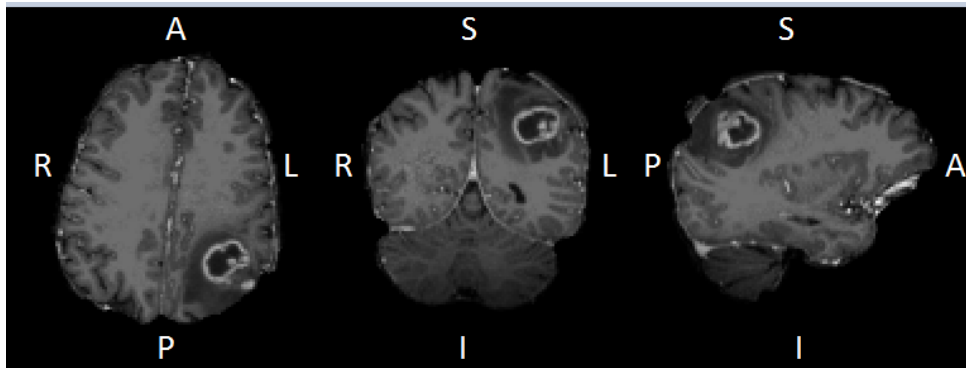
Contrast-enhanced T1-weighted axial, coronal and sagittal cuts of a patient with glioblastoma multiforme located in the left hemisphere (L-left, R - right, A - anterior, P - posterior, I - inferior, S - superior). In this image we can see an area of decreased density (necrotic tissue) surrounded by a bright ring from concentration of the enhancing contrasted dye, which gives us the tumour location. The low signal region surrounding the lesion corresponds to oedema presence.
